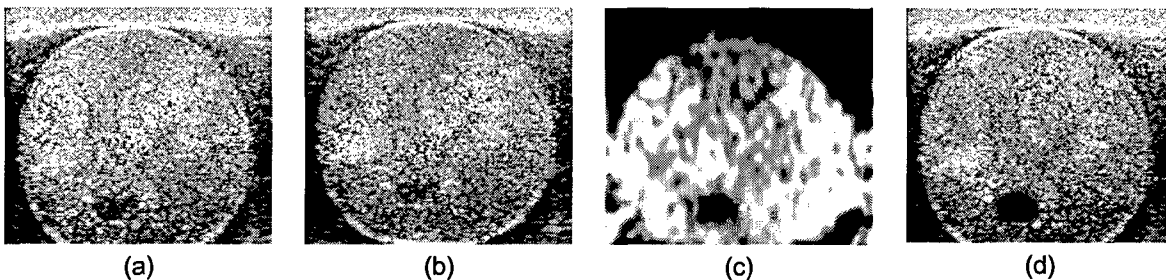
Ultrasound image of the prostate with two lesions a) before and b) after deformation applied with the ultrasound imaging probe. c) Strain image of the prostate initially identifying the harder lesion. d) Elasticity image overlaid on top of the ultrasound image indicating the prostate cancer.
